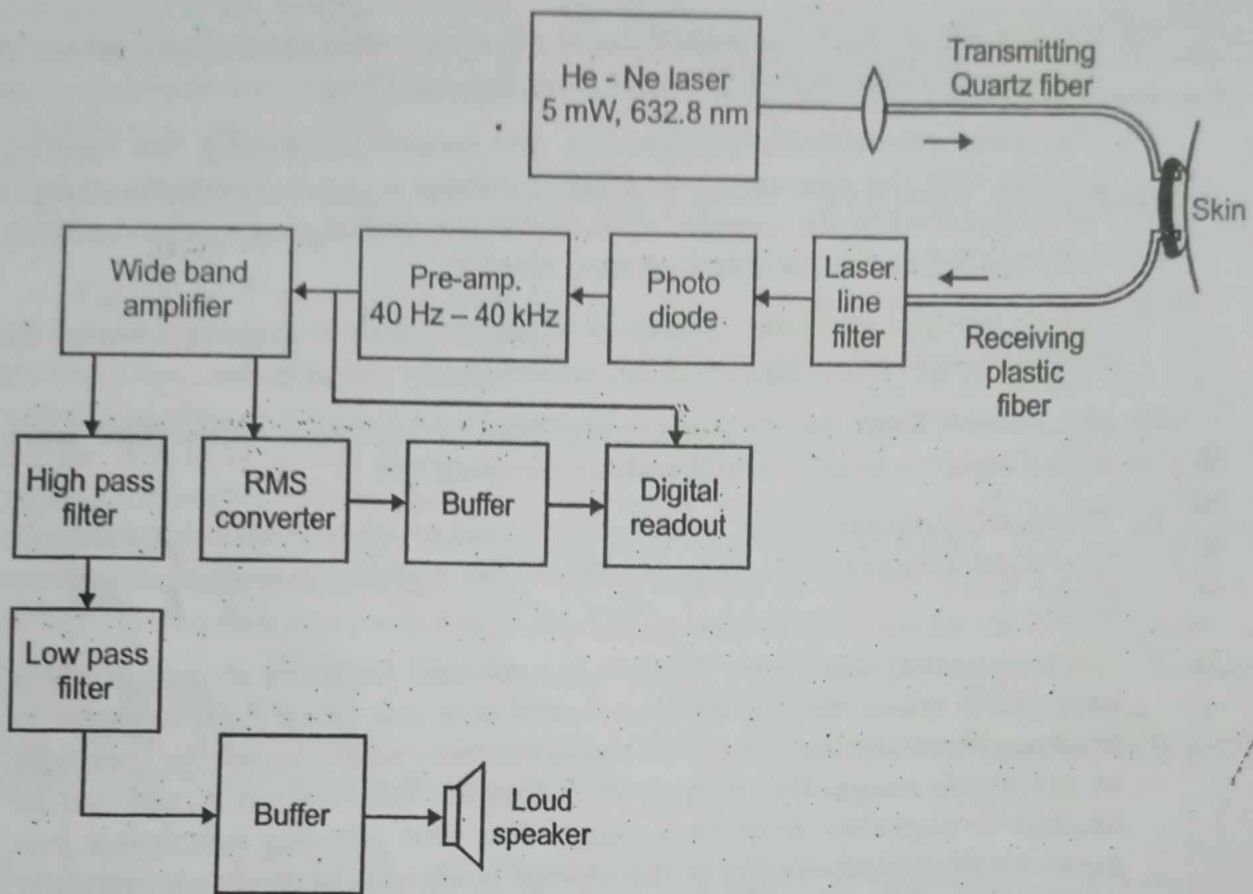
Laser doppler blood flowmeter
